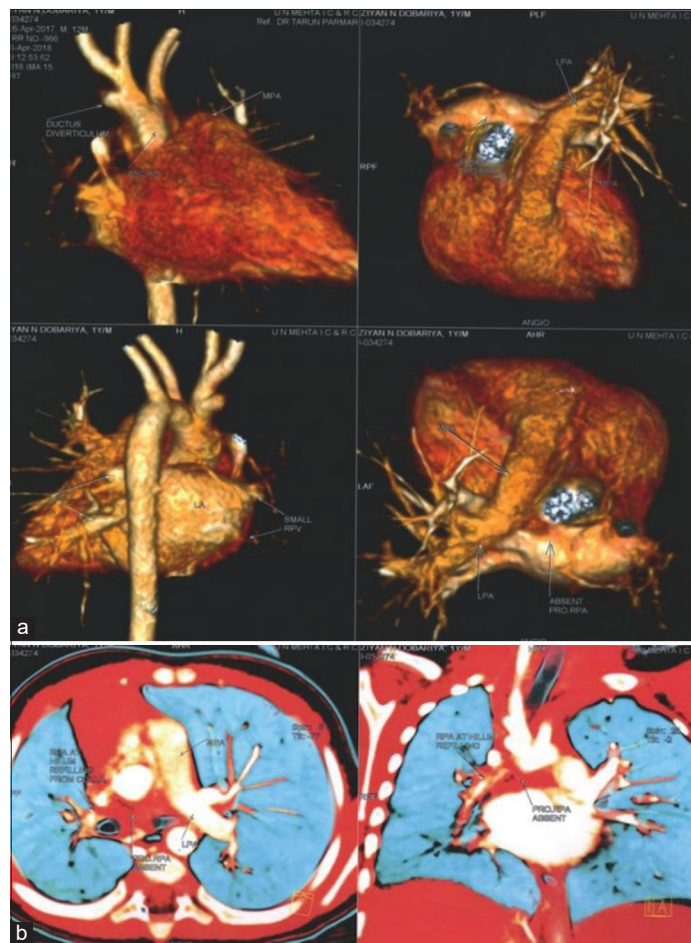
(a) The 3D reconstruction of the heart and its vasculature using a multiscan cardiac computed tomography scan demonstrating hypoplastic right pulmonary trunk, while the left pulmonary trunk is visualized normally; (b) The pulmonary vasculature with the help of contrast demonstrating the clear absence of the right pulmonary artery along with patent left pulmonary artery
